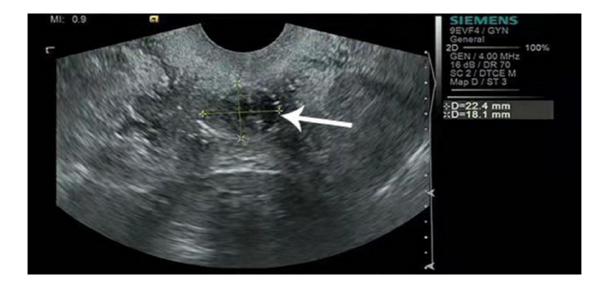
Ultrasound image of a vaginal leiomyoma
